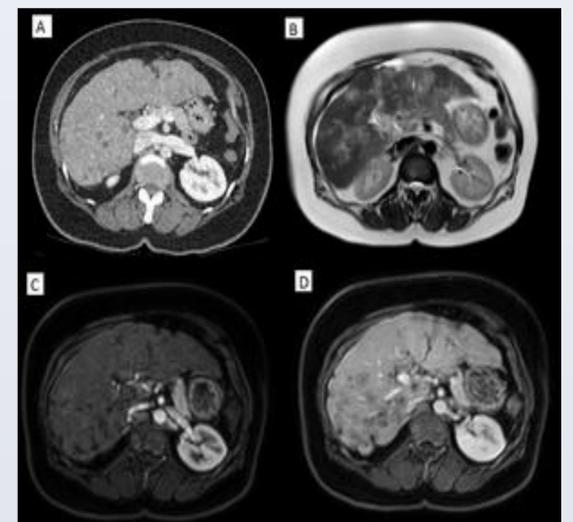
A. Contrast enhanced CT of pseudocirrhotic change with hepatic metastases. MRI images of the same patient performed shortly afterwards demonstrate these changes more clearly; B. axial T2 images C. T1 arterial contrast D. T1 portal venous contrast MRI images.
